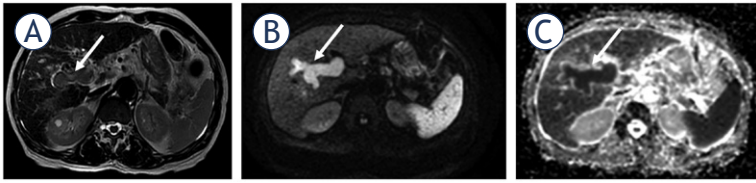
63-year-old man with chronic hepatitis C and HCC with tumor invasion within the portal vein. Main and right portal veins demonstrate dilation (arrows), high signal intensity on T2 weighted image (T2WI) (A), restriction on diffusion weighted imaging (DWI) (B,C).
